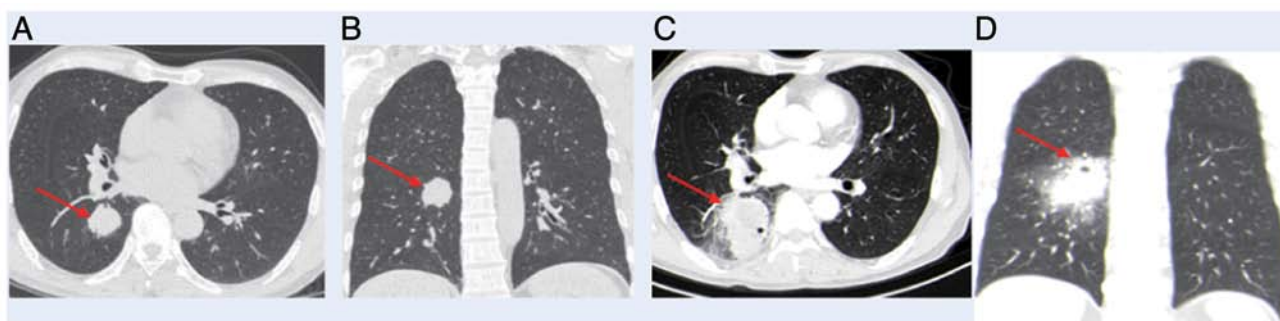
Results of chest CT examination. (A and B) Images at 5 days pre-admission. (A) Axial and (B) coronal CT scans of the chest, and the red arrow indicates a mass in the right lower lung. (C and D) Images at 1 day post-admission. (A) Axial and (B) coronal CT scans of the chest, and the red arrow indicates a right lower lung patch with cavitation. Lung cancer was suspected and infectious lesions complicated with abscess formation could not be ruled out. CT, computed tomography.
